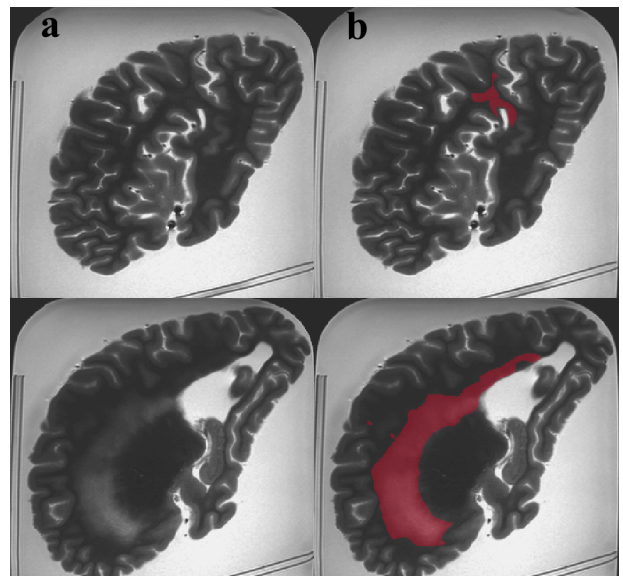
Examples of (a) raw ex-vivo T2-weighted images from a single brain hemisphere and (b) corresponding regions of WMHs in red.
